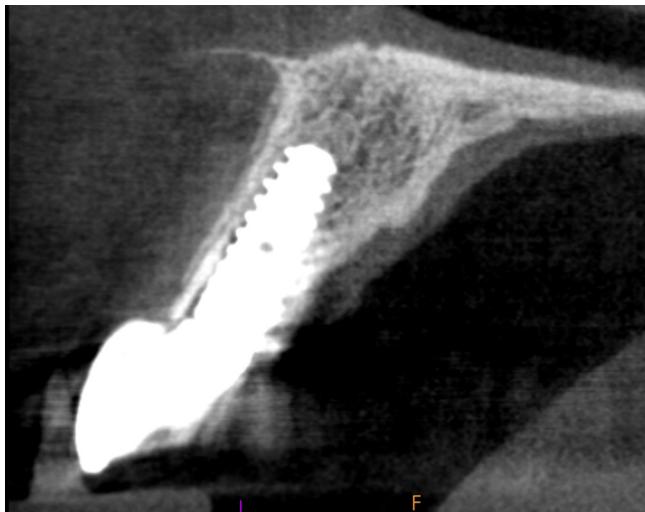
Four year follow up section of CBCT showing intact shield.
